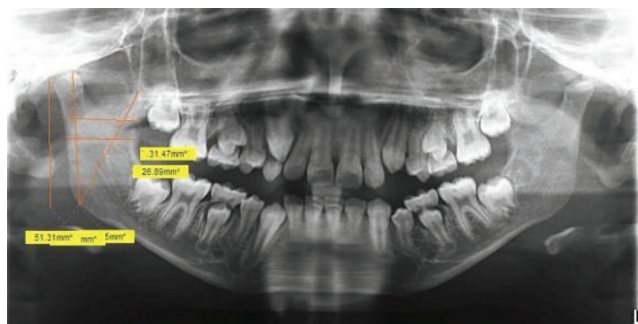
Measurements of mandibular ramus on panoramic radiograph
